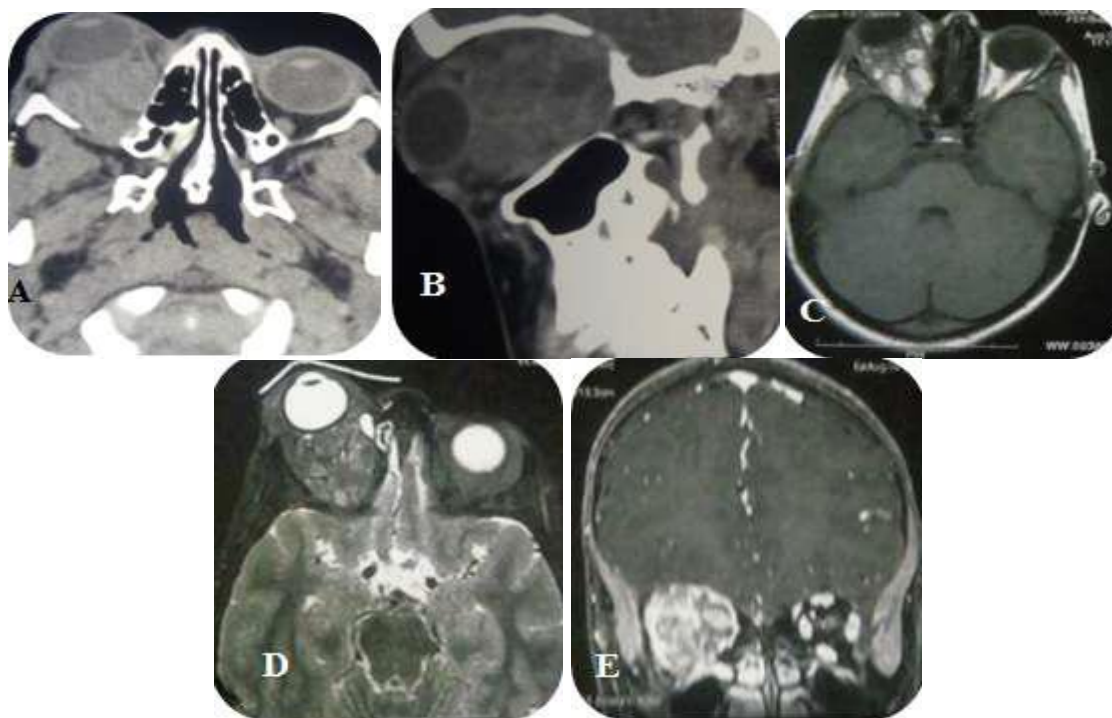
Cerebral CT in axial and sagittal section shows a microcystic infiltrating lesion of the right orbit. Brain MRI in axial and coronal T1 and T2 fat suppression section shows a heterogeneous process with microcystic phleboliths infiltrating the structures of the right orbit.
